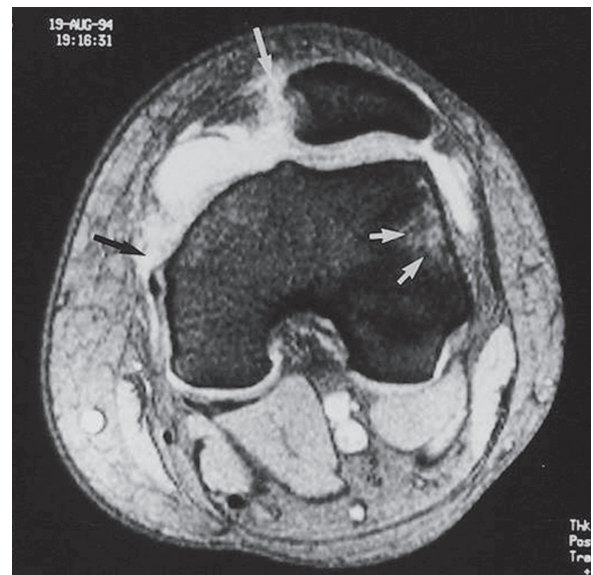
Axial MR image following lateral patellar dislocation. Note complete discontinuity of signal in the area of the MPFL (indicative of complete rupture) both at the medial femoral epicondyle (black arrow) and at the medial border of the patella (long white arrow). Lateral condylar marrow edema is also seen (short white arrows)
